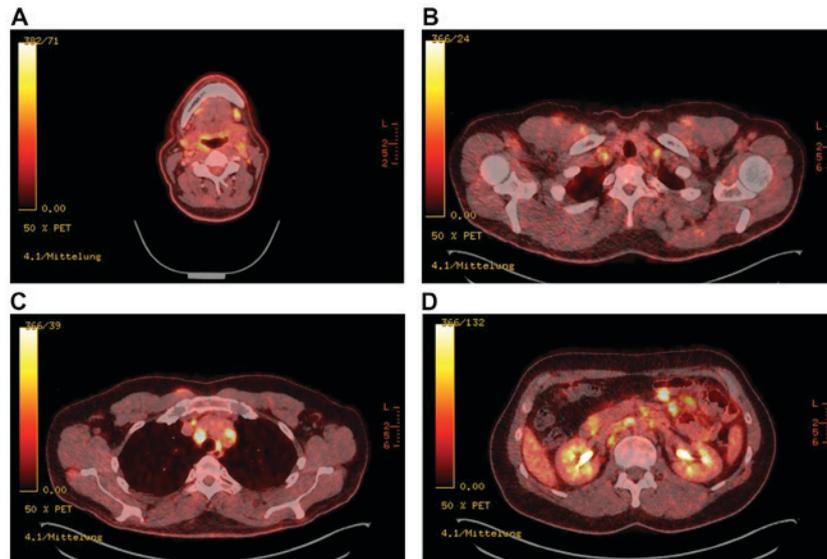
PET-CT showing multiple high uptake lesions: 18-Fluorodeoxyglucose positron emission tomography and computed tomography ( $^{18}\text{F}$ FDG-PET-CT) of a patient with a history of paranasal sinus adenocarcinoma shows increased uptake of (A) submandibular, (B) cervical, (C) mediastinal and (D) mesenteric lymph nodes suspicious of multiple metastatic lesions. Bioptical examination revealed cervical metastases of the known adenocarcinoma and mediastinal sarcoid-like lesions without malignancy. Courtesy of Professor W. Heindel, Institute of Clinical Radiology, University Hospital Münster.  $^{18}\text{F}$ FDG-PET-CT, 18-fluorodeoxyglucose-positron emission tomography-computed tomography.
